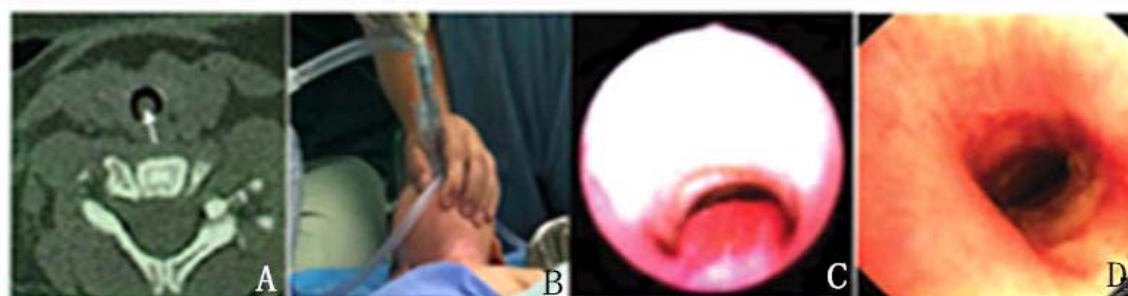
A) CT showing airway stenosis. B) Y-connector. C) Bronchoscopy photography showing a narrowest portion of the trachea. D) Bronchoscopy photography showing canalization of the trachea.
